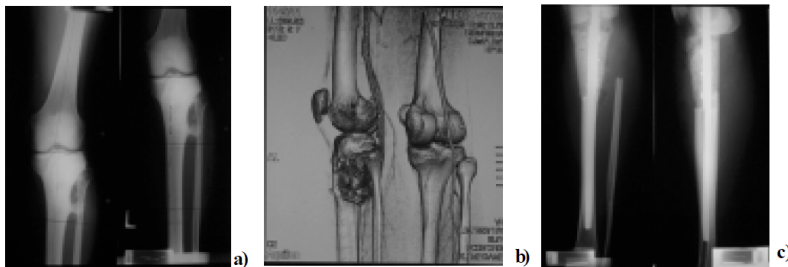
a) X-ray of the proximal tibia osteosarcoma; b) CT angiography of the osteosarcoma, with visualization of the arteries; c) X-ray after modified Campanacci resection arthrodesis of the knee.
